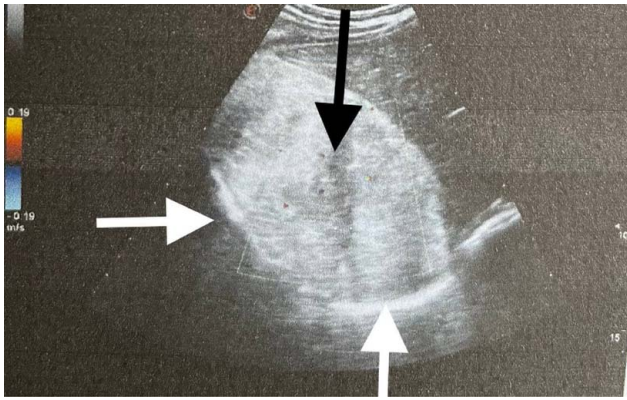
Doppler ultrasound. Revealing a capsulated (white arrows) hyperacoustic mass (black arrow).
